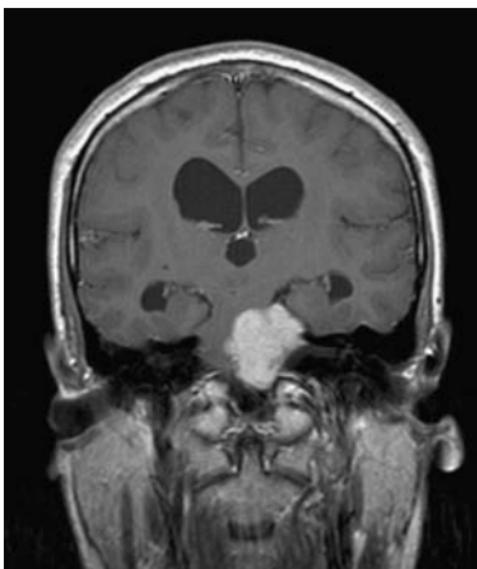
Large vestibular Schwannoma. (a) Axial T2W and (b) post-contrast enhanced coronal MRI. Large lobulated homogeneously enhancing extra-axial mass, (denoted by the CSF cleft (white arrow)), in the left CPA cistern extending for a short distance into the internal auditory canal. There is marked distortion of the pons with effacement of the fourth ventricle, mainly on the left (black arrowheads). The hyperintensity on T2W imaging and lack of dural attachment are in keeping with a vestibular Schwannoma rather than a CPA cistern meningioma. Note that effacement of the fourth ventricle has resulted in hydrocephalus with dilatation of the third and lateral ventricles.
